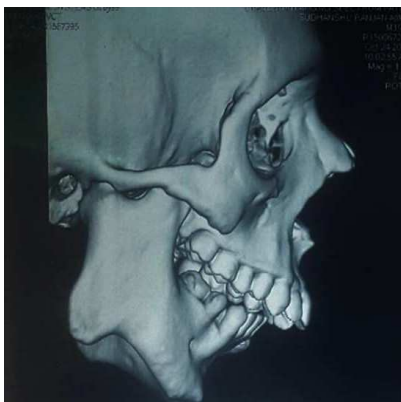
Pre Operative CT Scan 3D (Right)
